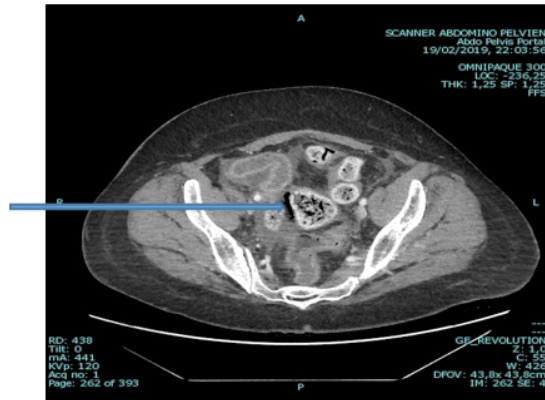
CT scan showing sigmoid colon perforation Secondary to fecaloma (Blue arrow).
